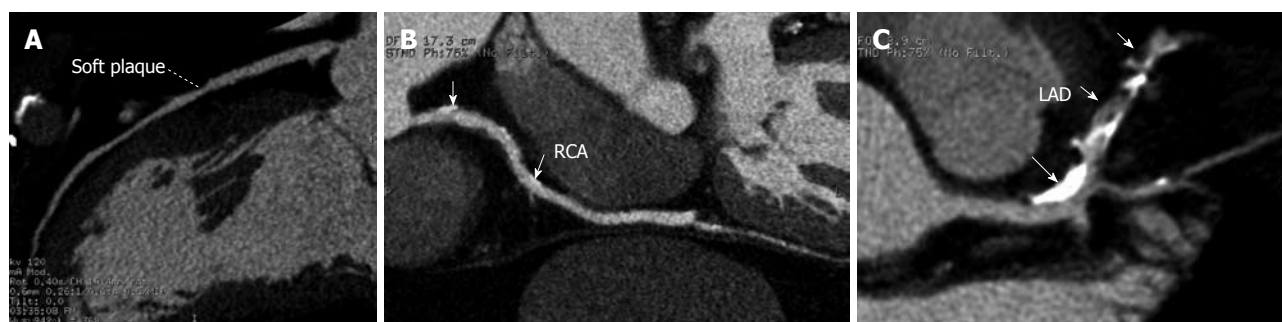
Characterization of coronary plaques. RCA-right coronary artery. A: Curved planar reformatted image acquired with 64-slice computed tomography angiography shows a non-calcified plaque at the mid-segment of the right coronary artery in a 57-year-old man suspected of coronary artery disease; B: Calcified plaques (arrows) are found at the proximal and middle segments of the right coronary artery; C: Mixed type plaques are shown in the left anterior descending (LAD) artery in a 59-year-old man suspected of coronary artery disease; the long arrow indicates the calcified plaque, while the short arrows indicate non-calcified components.
